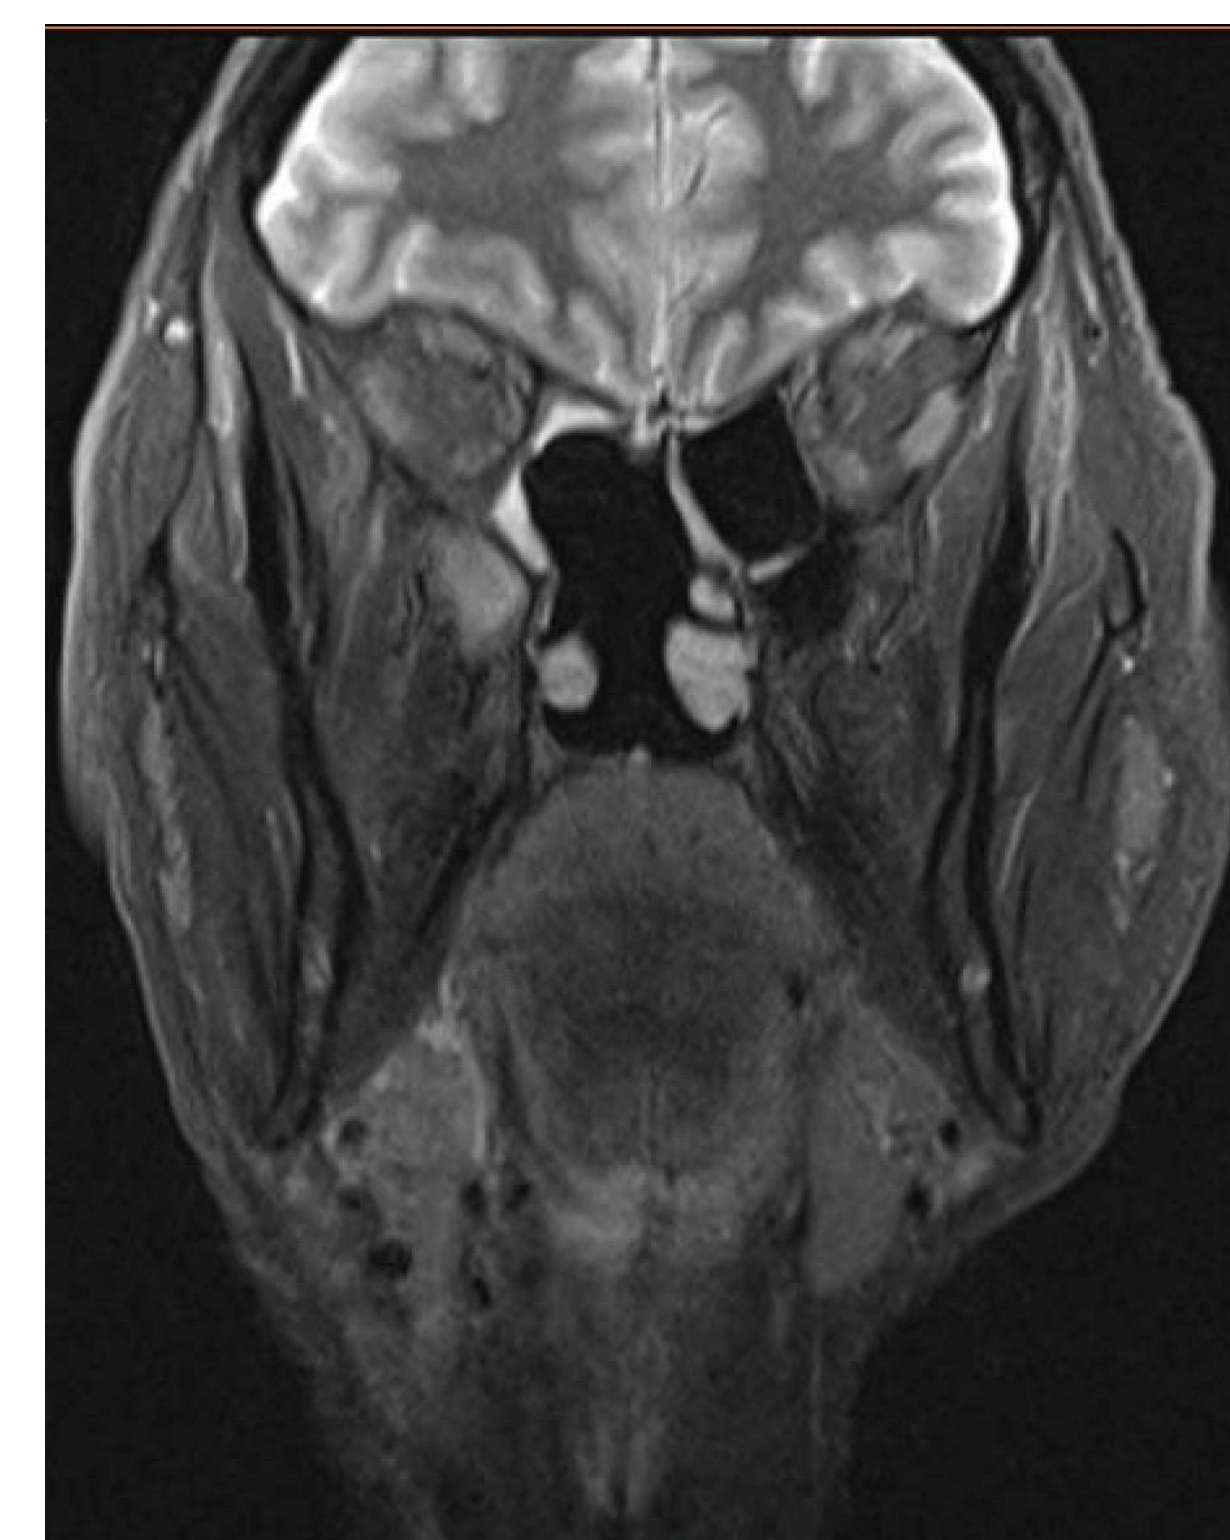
MRI post surgical excision.
